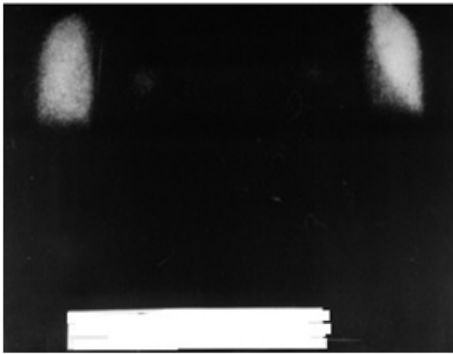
Lung scan scintigraphy three days after the accident
